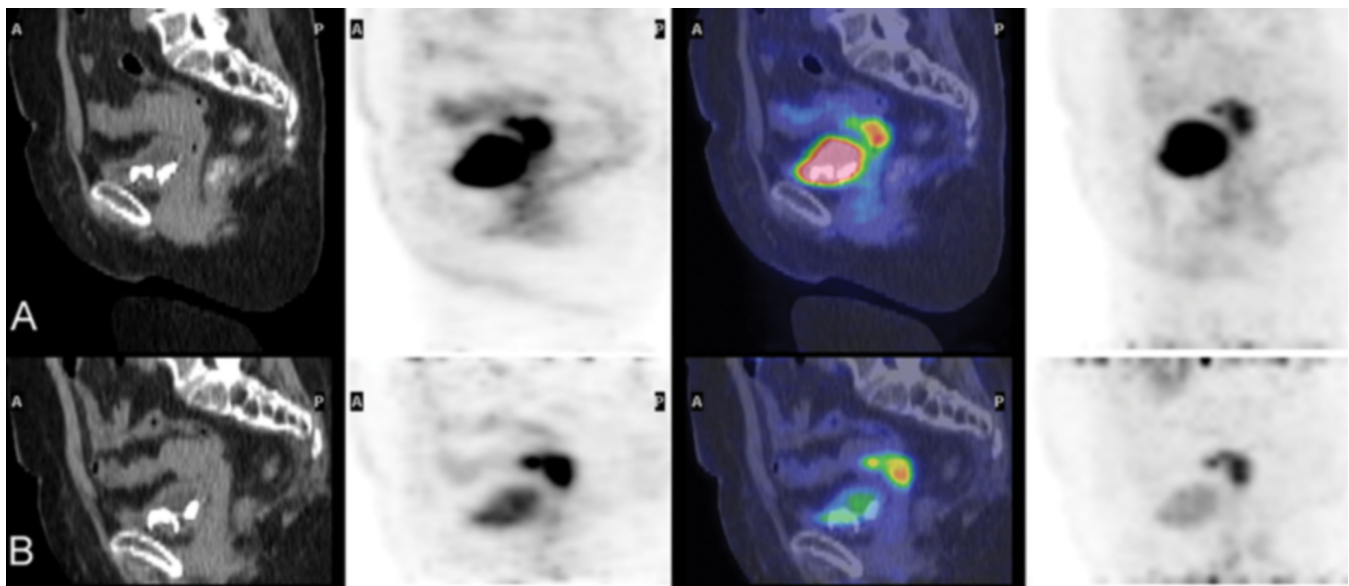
66-year-old woman previously treated for cervical cancer, with suspected recurrence. Sagittal images at the bladder level, CT scan, PET scan, fusion, and Maximum Intensity Projection (MIP). A. At one hour post injection, PET shows an abnormal (18F)-FDG close to the bladder. B. At two hours post injection, the kinetics of the abnormal uptake make it possible to characterize the lesion.
